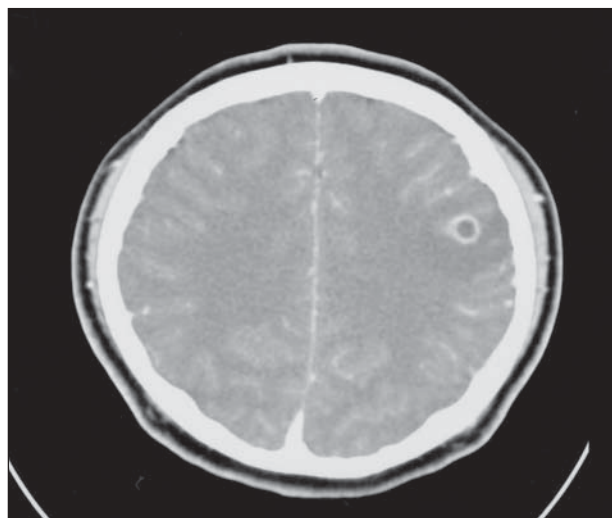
Contrast-enhanced computed tomographic scan of the brain, demonstrating a 1-cm focal hypodensity in the left frontal lobe with rim enhancement and an associated zone of vasogenic edema.
